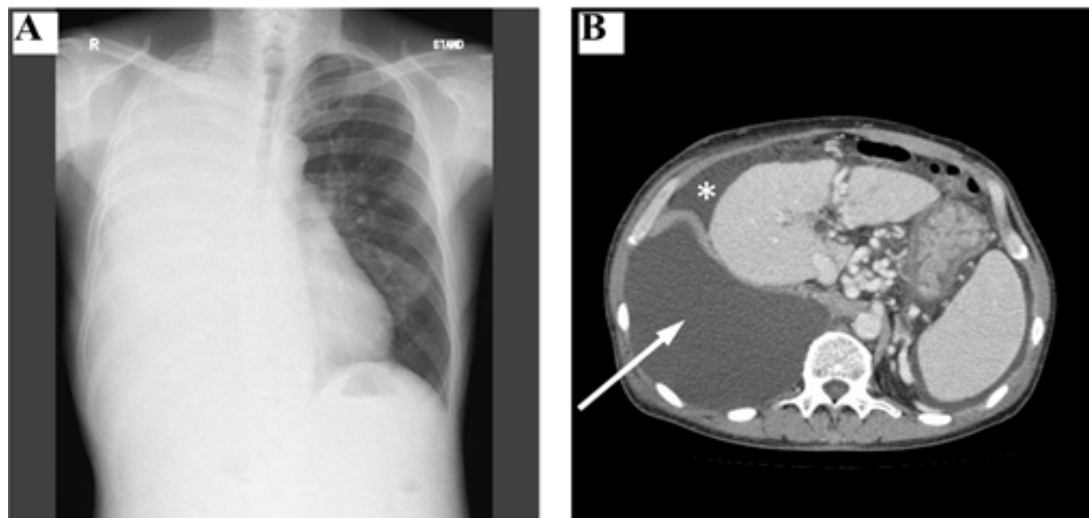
A. Chest X-ray taken on the day of admission showing significant right-sided hydrothorax. B. Abdominal contrast-enhanced computed tomography taken 27 days before admission showing hydrothorax (→) and a small amount of ascites (*).
